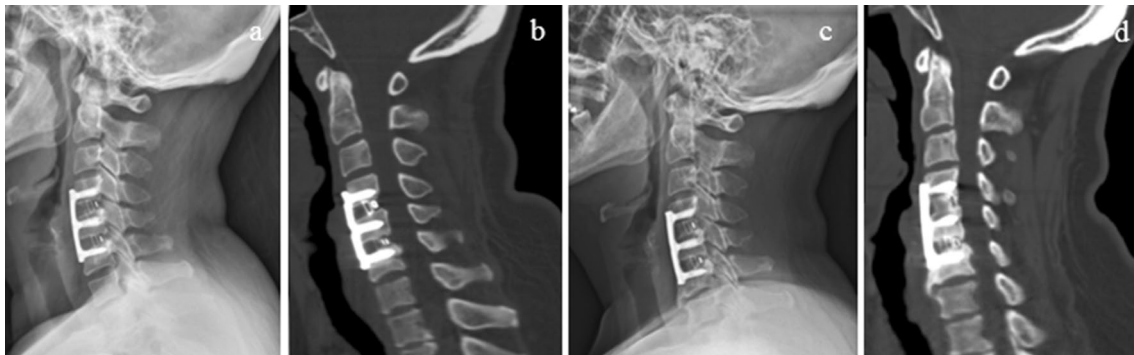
Serial follow-up for a 52-year-old female who received C4/5 and C5/6 ACDF with empty cages. a 12 months postoperative lateral radiograph; b sagittal-view CT scan showing not fused at 12 months;
